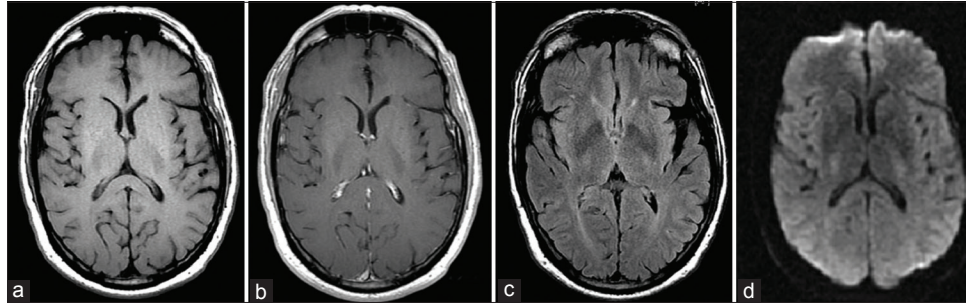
Preoperative axial T1-weighted MRI without contrast (a), with contrast (b), FLAIR (c), and diffusion-weighted sequences (d) demonstrating no evidence of thalamic infarct or encephalomalacia.
